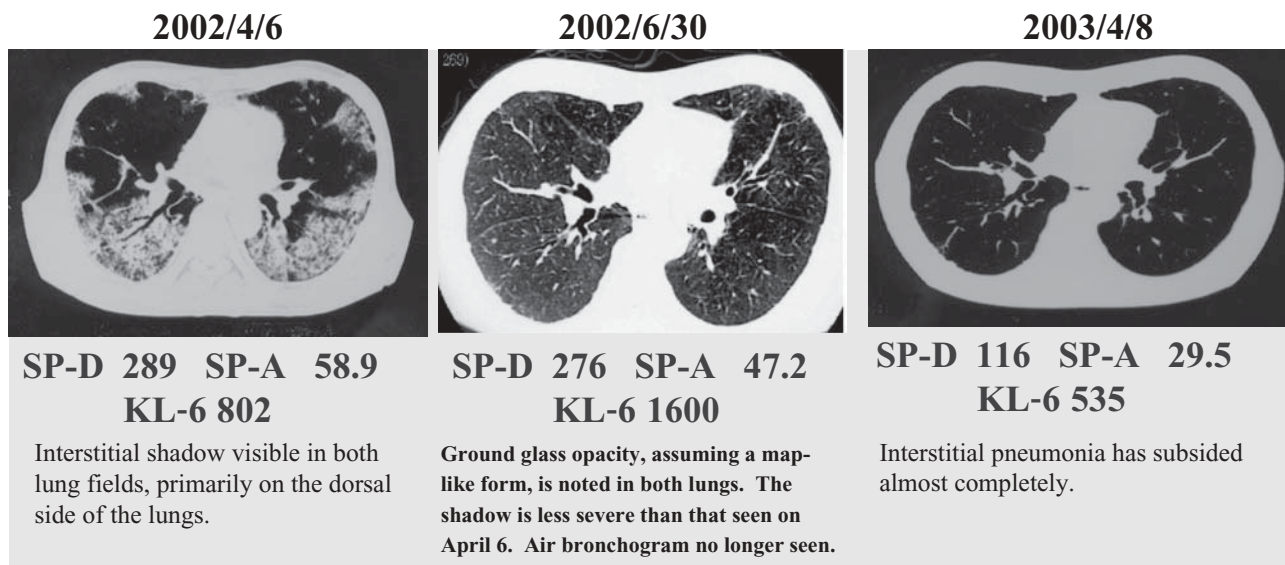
Chest computed tomography scans. *SP-D*, surfactant protein D; *SP-A*, surfactant protein A
